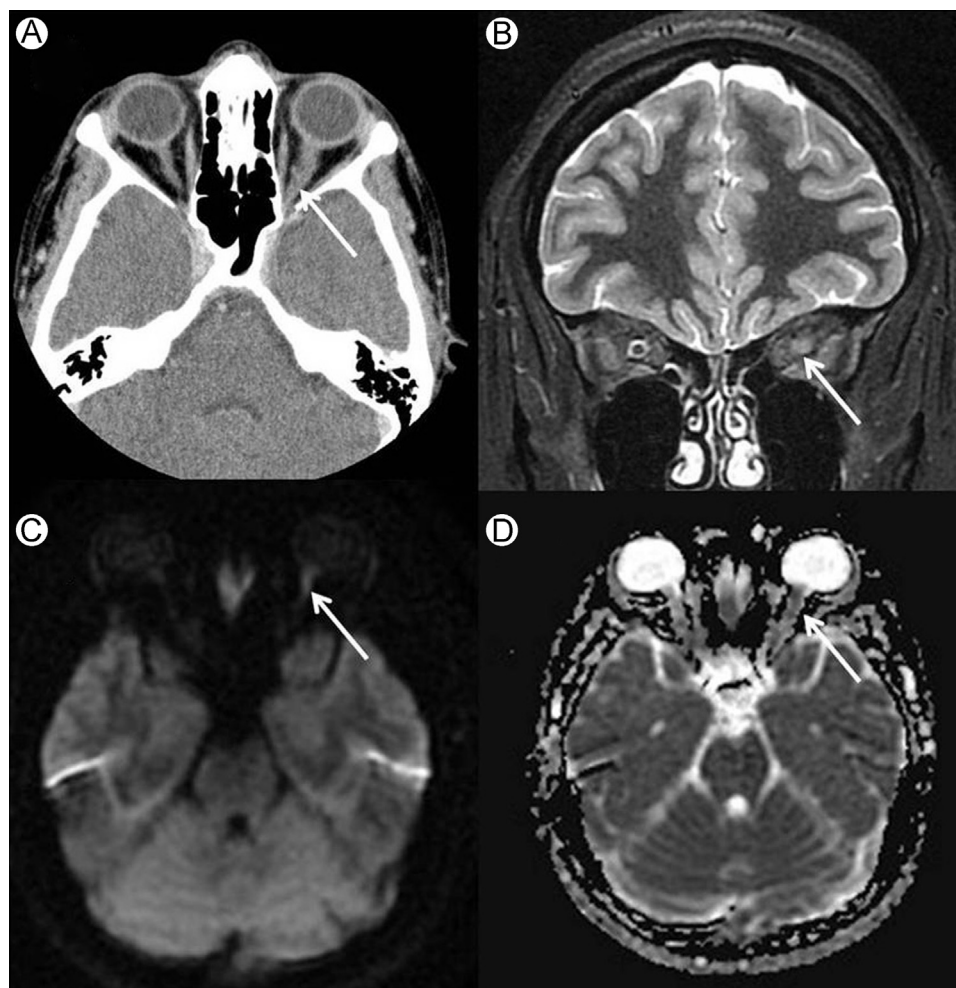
Optic neuritis: (A) axial CT showing mild left optic nerve enlargement (arrow, compare with right); (B) coronal STIR image showing enlarged left optic nerve (arrow) with effacement of surrounding CSF in the nerve sheath (compare with right); (C) axial DWI; and (D) ADC map. In acute cases there is evidence of mild diffusion restriction (arrows, C and D). ADC, apparent diffusion coefficient; CSF, cerebrospinal fluid; CT, computed tomography; DWI, diffusion-weighted imaging; STIR, short tau inversion recovery.
